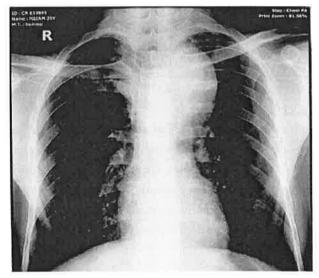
Chest X-ray showing well circumscribed dense homogenous opacity occupying the left upper zone with medial border merged with mediastinal shadow, trachea shifted to the right.
